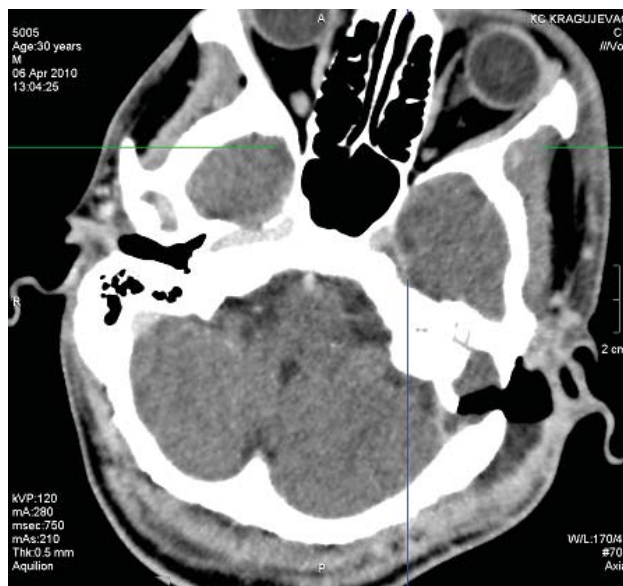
Computed tomography (CT) reveals hypodense collection with gas content subcutaneously in the left temporoparietal region, filling the mastoid cavity and entering into the sinus sigmoideus and posterior cranial fossa
